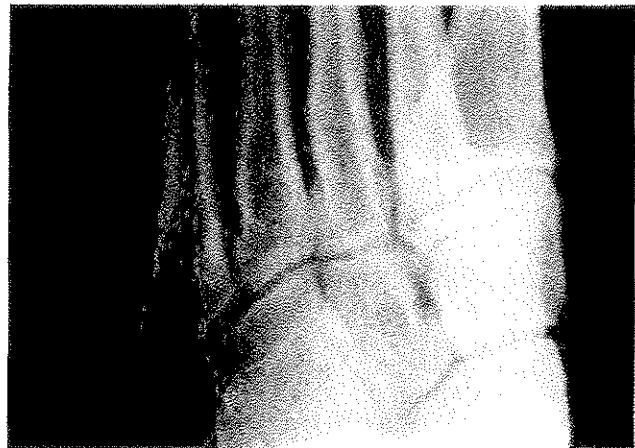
Plain film: medial oblique radiograph of the foot. There is no osseous or joint disease identified. Particular attention to the base of the third metatarsal articulation shows no abnormality (Courtesy of Dale G. Huntington, D.C., D.A.B.C.O., Springdale, Arkansas.)
